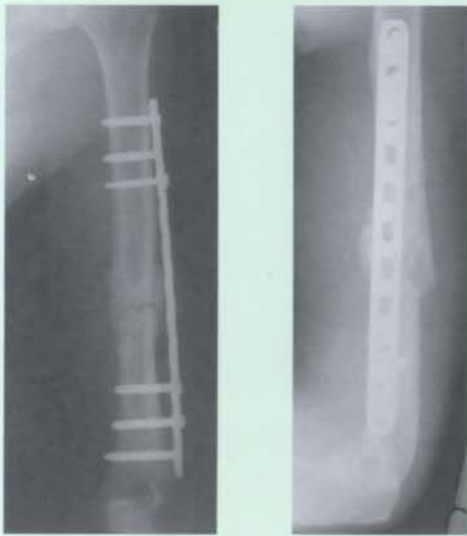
2de Radiographs at 2 months follow-up showing rapid callus formation
